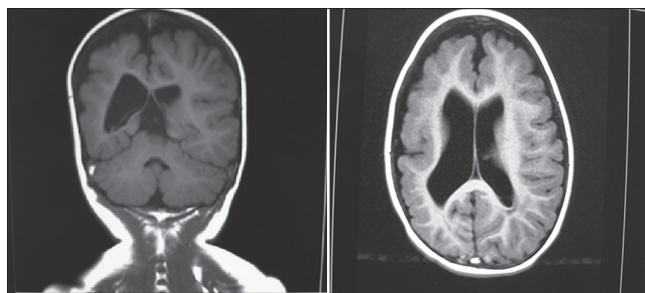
Magnetic resonance imaging of case
